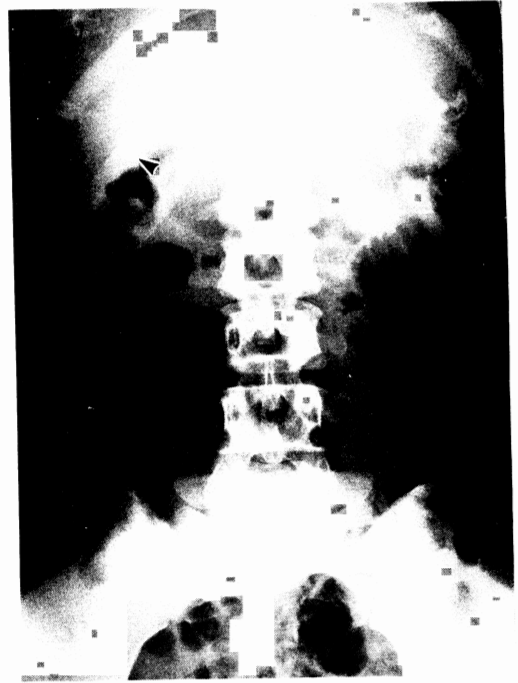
Abdominal X-ray of the patient. Stone-like shadow was seen just under the right lobe of the liver (arrow).
